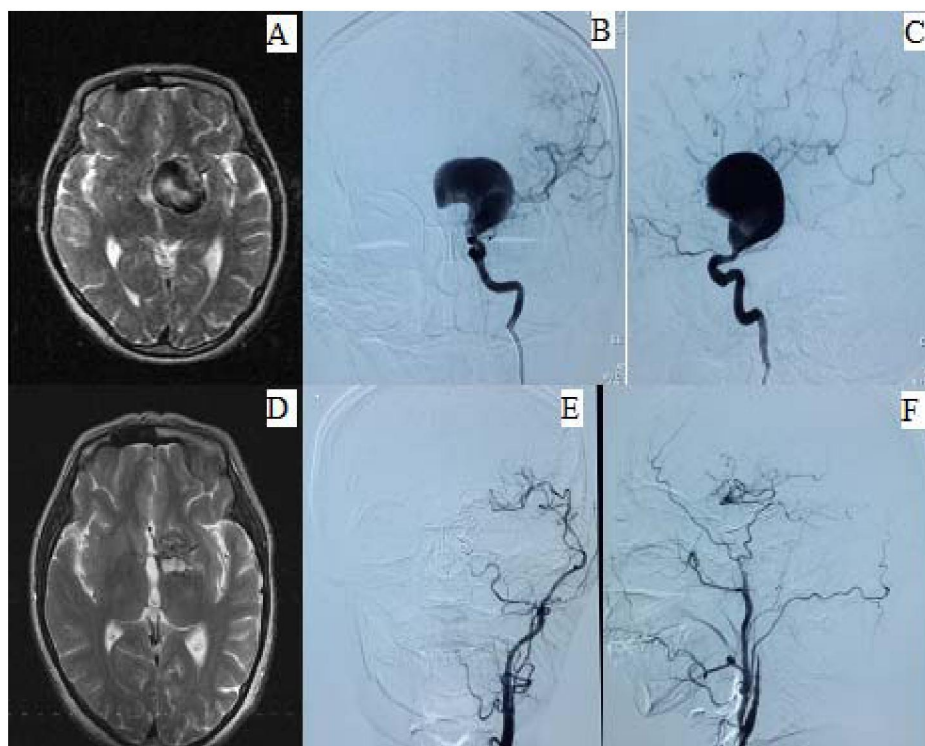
Female, 36 y.o. Giant aneurysm of left paraclinoid ICA (A, B ,C). STA-MCA bypass with endovascular occlusion of ICA at the level of ophthalmic artery origin. MRI and DSA after 6 months demonstrates exclusion of the aneurysm, volume decrease and bypass patency (D, E, F)
